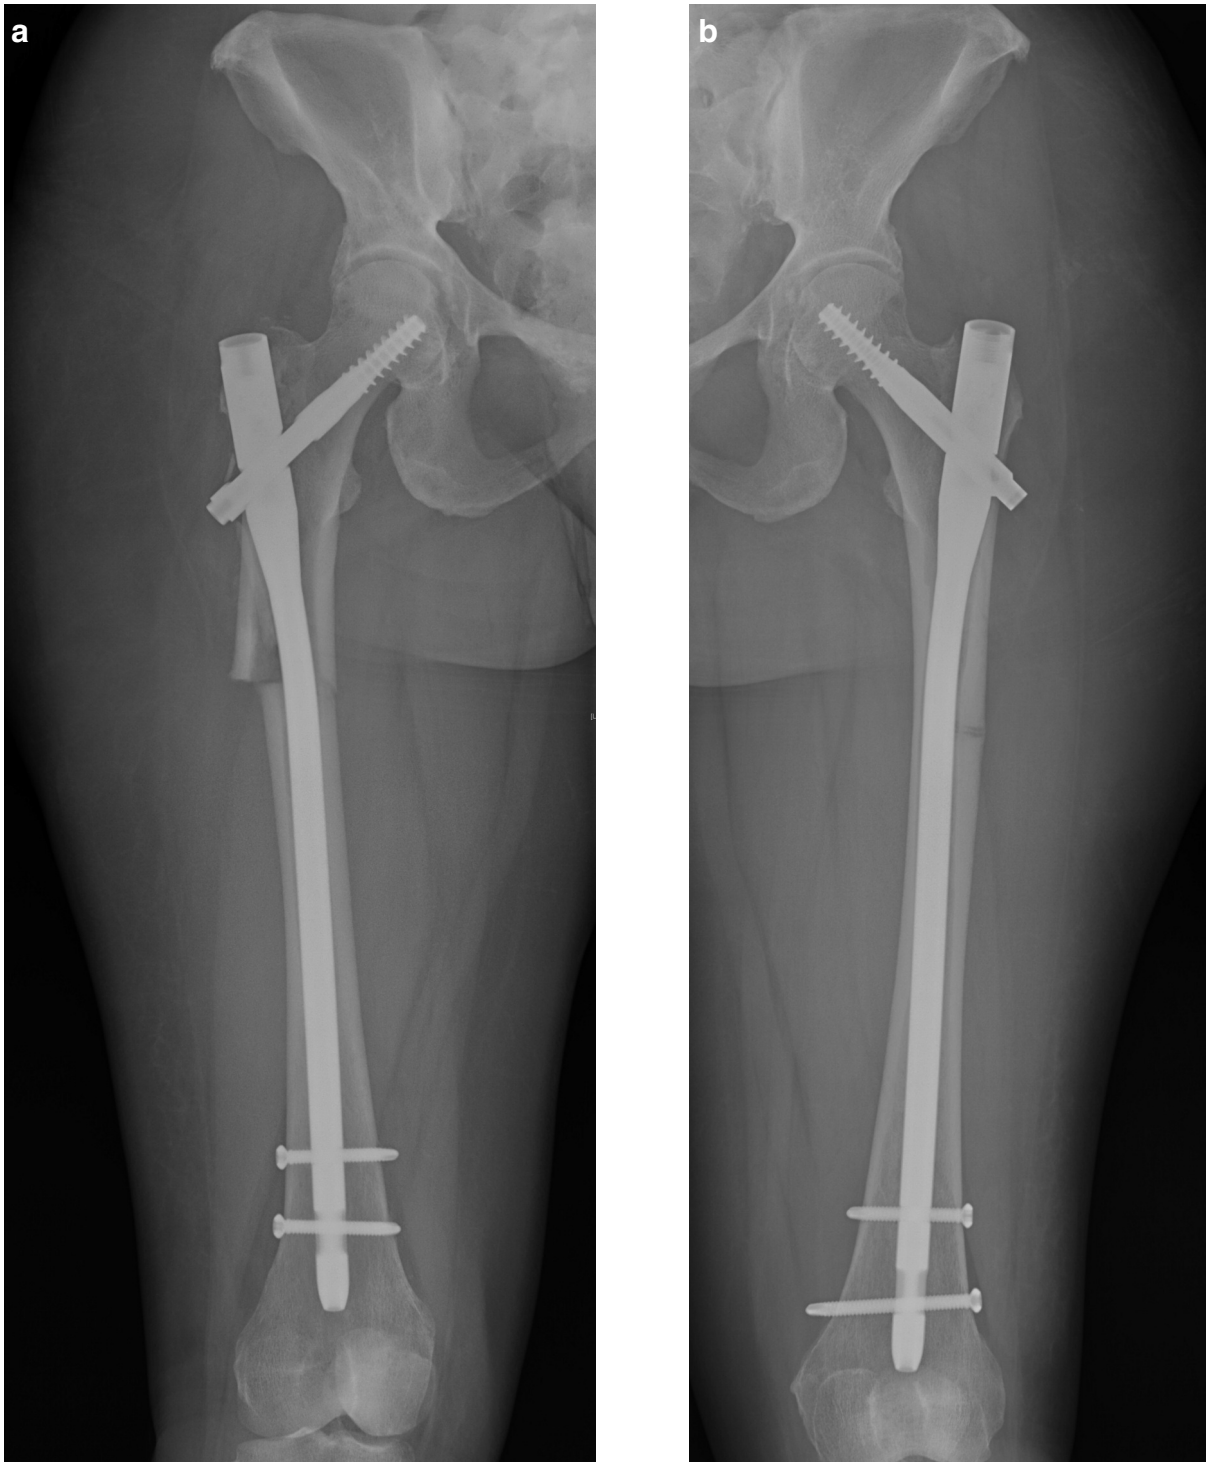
a, b - Post operative radiographs of both femora following intramedullary nailing.
